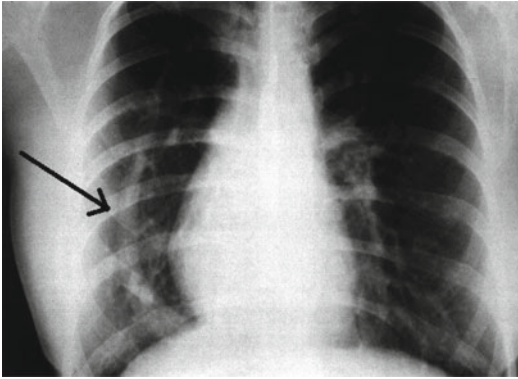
In the scimitar syndrome, one or all of the right PVs connect to the IVC making a curved sword appearance (resembles Turkish sword) on the chest X-ray associated with right lung hypoplasia and dextroposition of the heart. Abnormal pulmonary vein connecting IVC (arrow)
